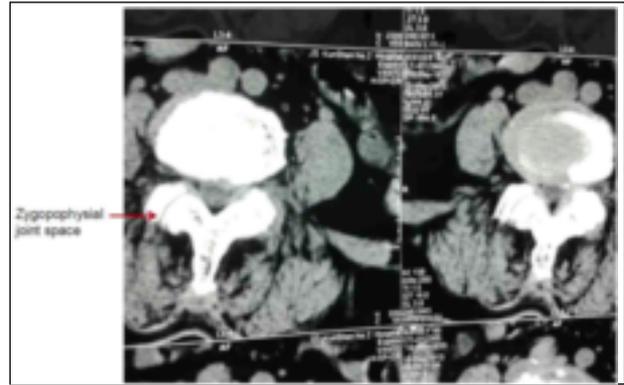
Zygapophysial joint space. Left, CT spine examination indicates recovered left zygapophysial joint space. Right, an asymmetric alteration.
